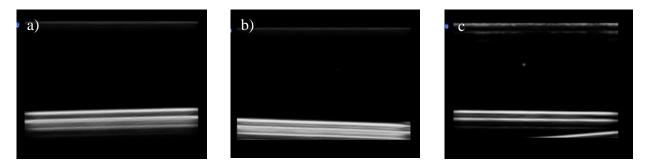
Ultrasound images showing the transparency of (a) poloxamer solution, (b) D5W, and (c) poloxamer gel on an ultrasound.
